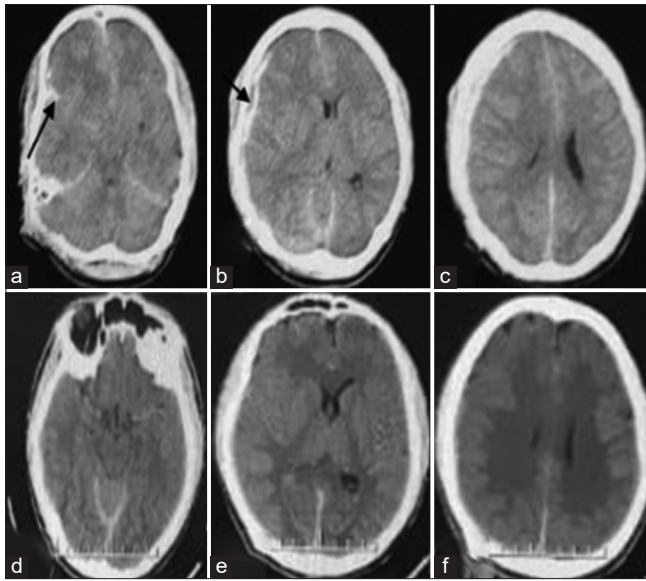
(a) (1 h) Basal cuts computed tomography scan showing SAH in distal right sylvian fissure (black arrow). (b) (1 h) Mid axial computed tomography scan showing thin layer of hypodensity (black arrow) seen between the inner table of bone and acute subdural hematoma with a midline shift. (c) (1 h) High parietal axial computed tomography scan showing thick acute subdural hematoma present at the high frontoparietal region with obliterated cortical sulci. (d) (6 h) basal axial cuts of computed tomography scan showed opened basal cistern with a resolution of the right sylvian SAH. (e and f) (6 h) Mid and high parietal axial computed tomography scan showing marked resolution of acute subdural hematoma seen, with reduction of midline shift
